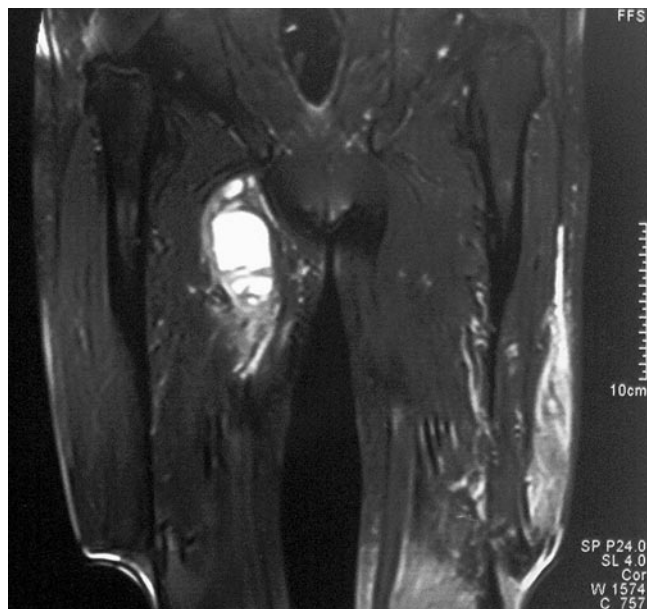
Magnetic resonance image of the left lower extremity showing a multiloculated cystic mass, measuring about 10 by 3 cm.
